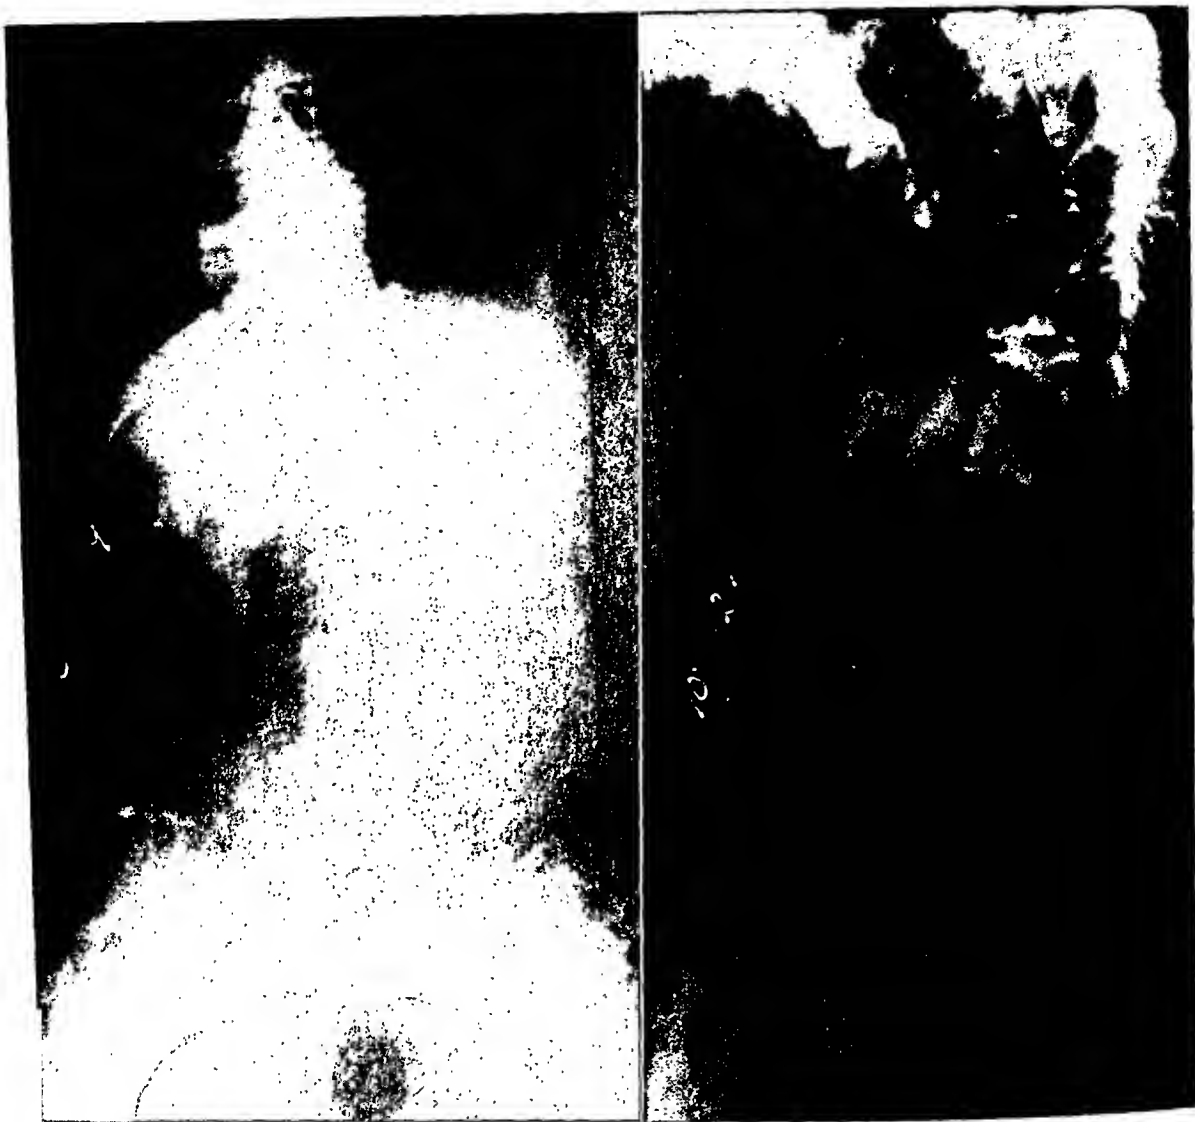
Case 3. Following X-ray treatment, there was some increase in the density of the vertebræ.
